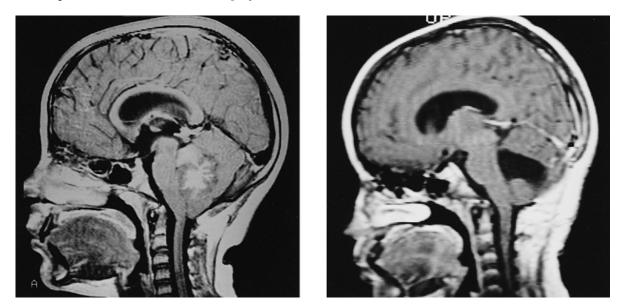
T₁-weighted sagittal MRI: pre-operative showing a medulloblastoma of the IV ventricle with intense enhancement (*left panel*) and post-operative showing a large demolition of the inferior vermis lobules that was associated with an autistic-like picture (*right panel*).
